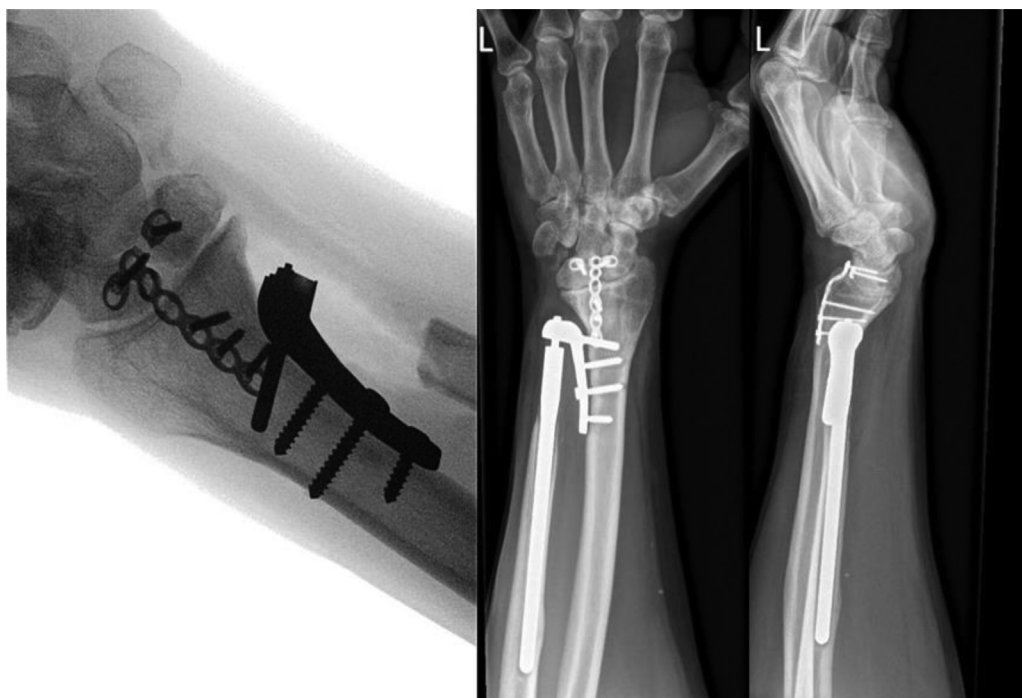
Anteroposterior and lateral X-rays of dislocation of the radial component 4 months after adequate placement of the Aptis distal radioulnar joint (DRUJ) implant, most likely as a result of poor bone stock in a patient with rheumatoid arthritis. Note the radioscapulohumeral nonunion.
